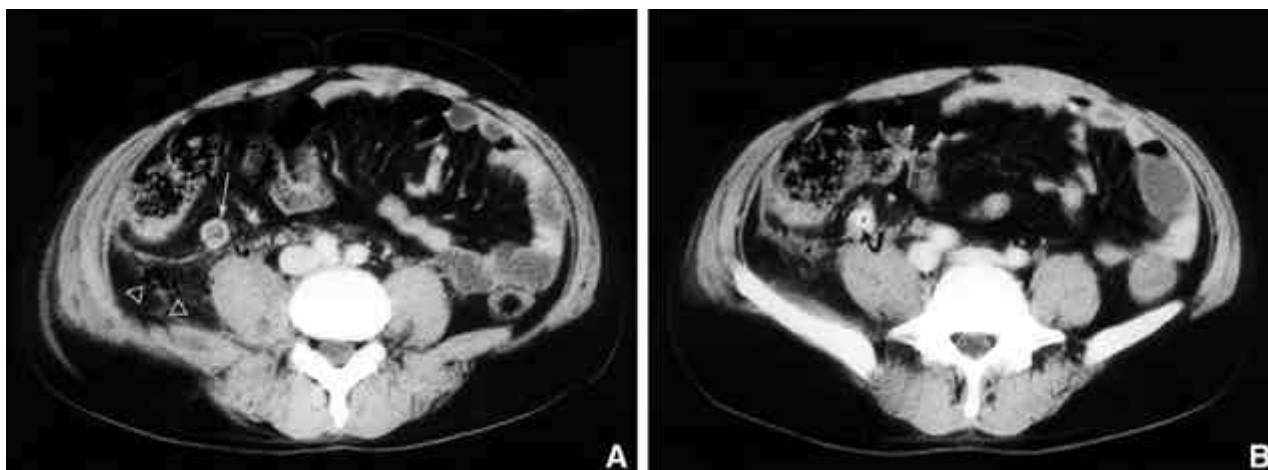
Perforated appendicitis. A: Contrast-enhanced CT shows distended appendix (arrow) with thickened wall. Also noted are thickened adjacent parietal peritoneum, diffuse periappendiceal stranding, and extraluminal air collection (arrowheads). B: Contrast-enhanced CT caudad to the level (A) shows hyperattenuated appendicolith (arrow) in the tip of the distended appendix.
